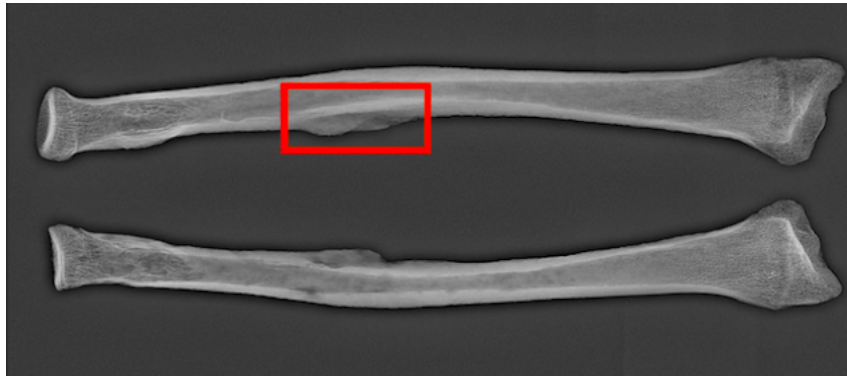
Nr. 14, InvNr 27997, Grave ID 334: x-ray of the soft-tissue trauma on the right radius (photographed by A.Wagner)
